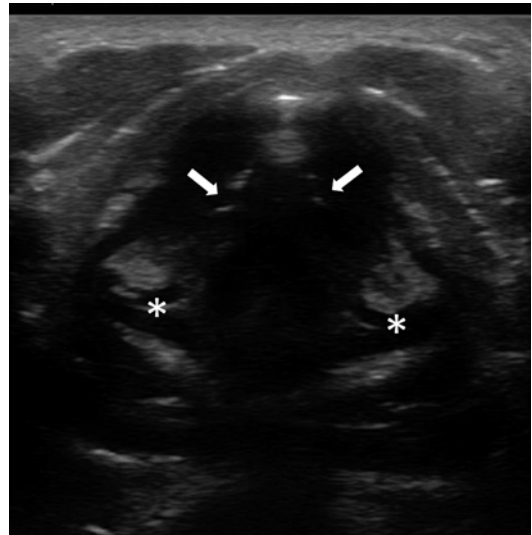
Laryngeal ultrasound. The true vocal folds appear as hypoechoic structures with a hyperechoic medial border, representing the vocal ligament (*arrows*). The arytenoid cartilages are seen posteriorly (*asterisks*)
